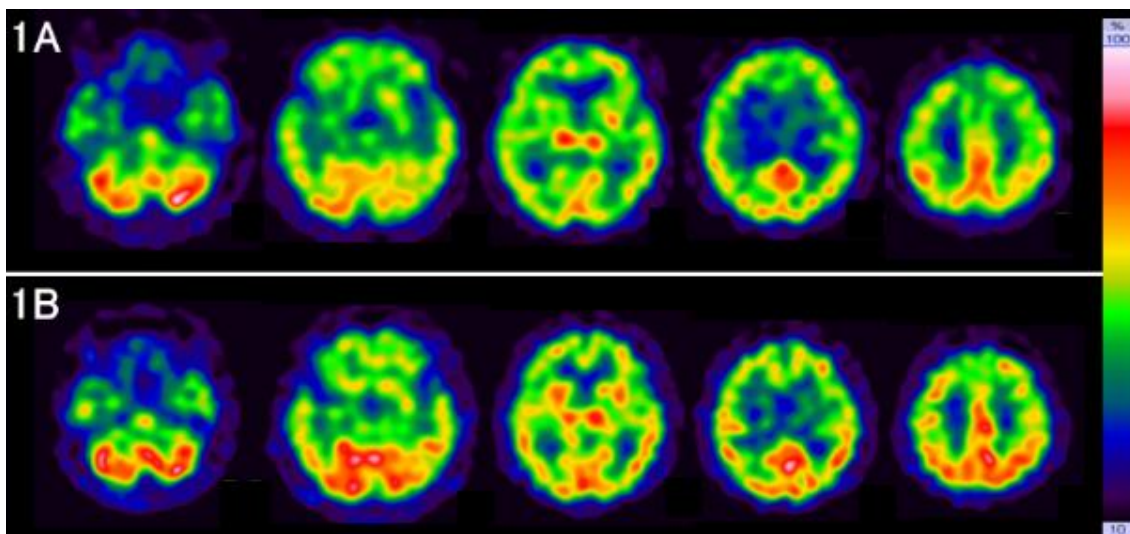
SPECT images before MHs (1A, upper) and during MHs (1B, lower). MHs, musical hallucinations; SPECT, single photon emission computed tomography.
